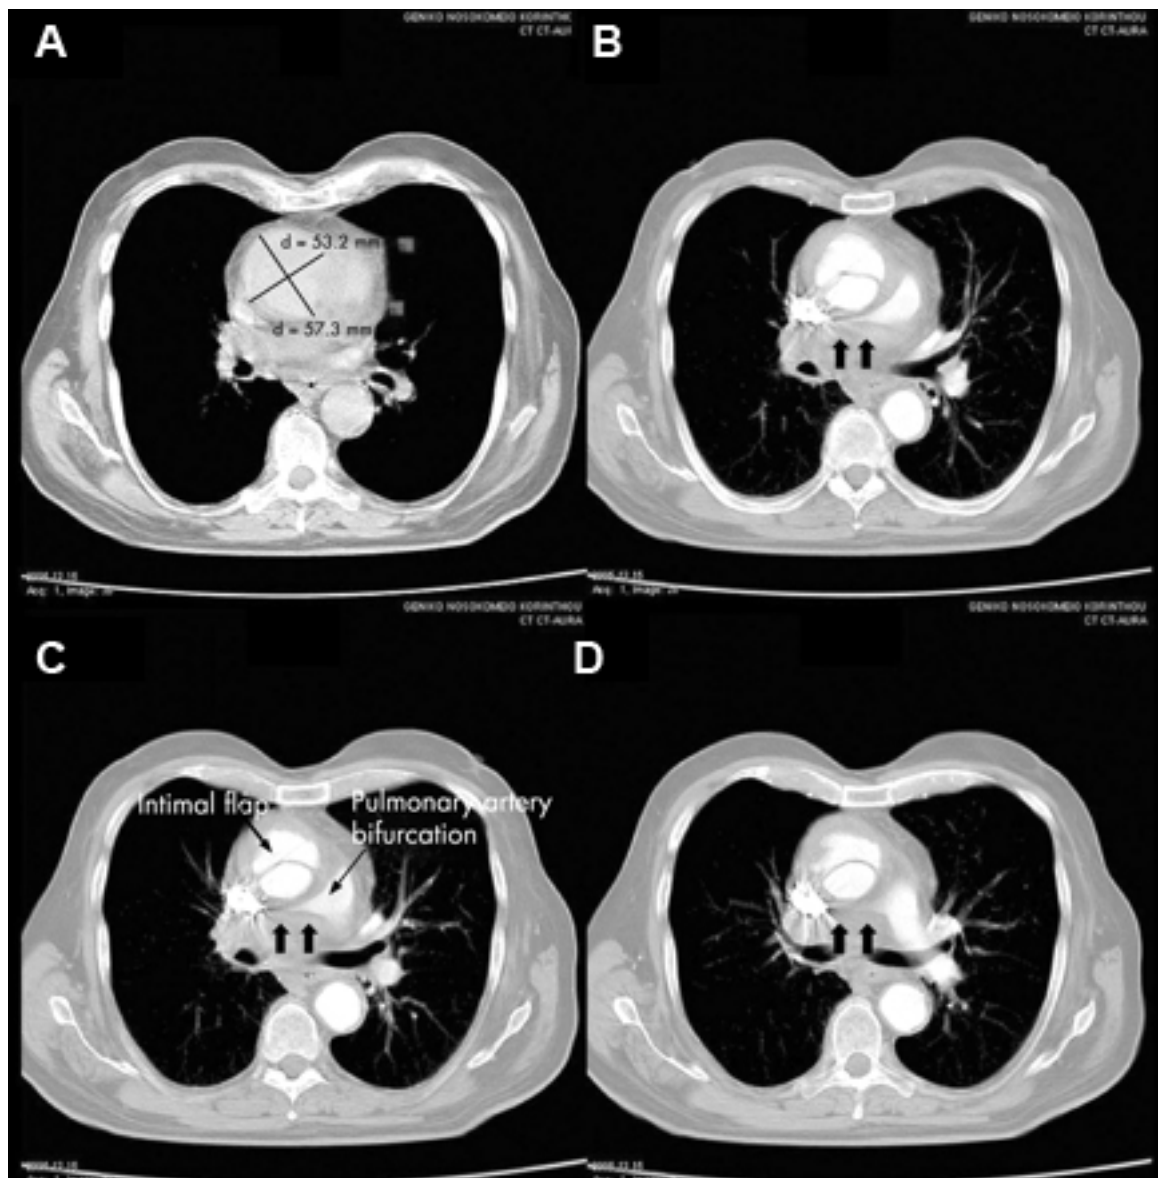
CT of a 71-year-old man showing type II dissecting aneurysm of the ascending aorta. Haematoma around the proximal segment of the ascending aorta (panels A-D) compressed the right pulmonary artery, almost occluding its patency and limiting the perfusion of the reciprocal lung
